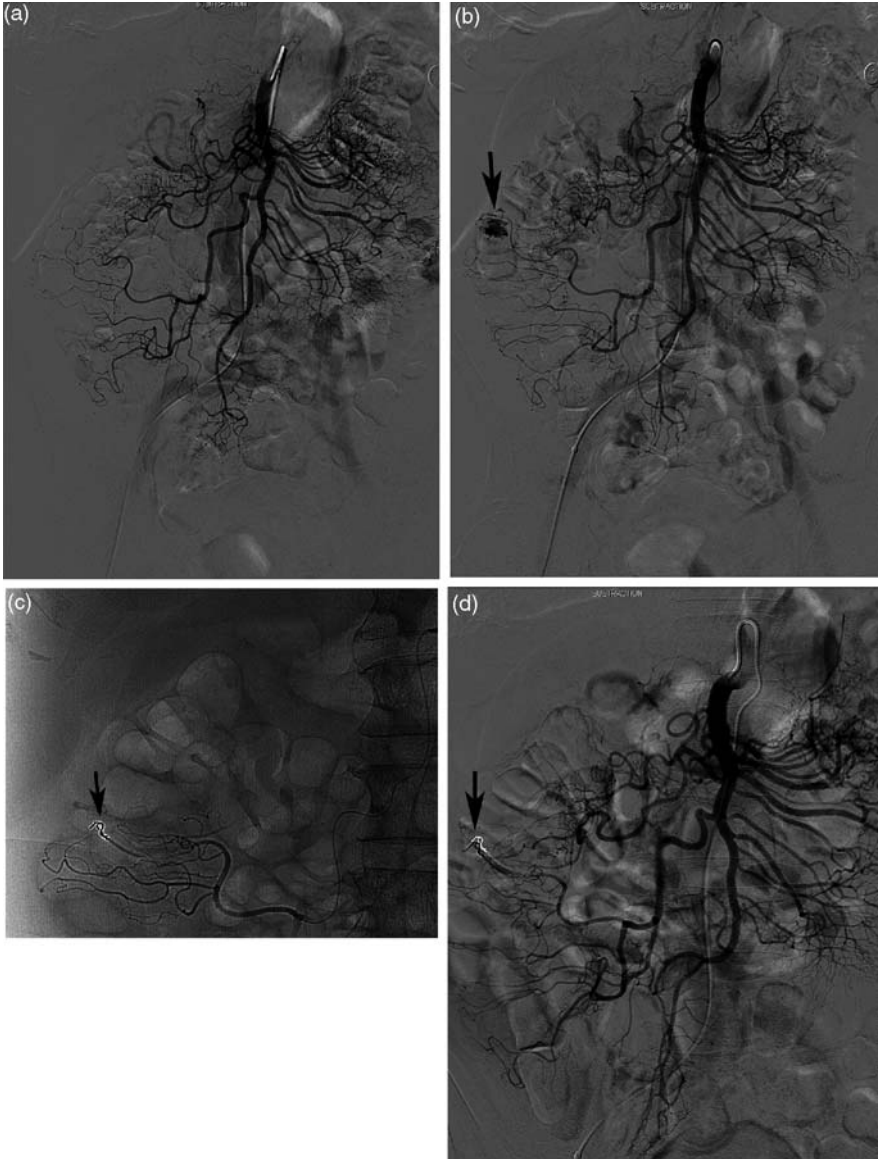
(a) 53-year-old male presents with positive scintigraphy in the hepatic flexure, transient hypotension with prior bleeding episode, and one previous negative arteriogram. Initial injection of the superior mesenteric artery is normal without extravasation. (b) Injection of the superior mesenteric artery following the administration of 5,000 U Heparin, 200 mcg Nitroglycerin, and 4 mg tPA demonstrates active bleeding (*arrow*) from a branch from the right colic which was suspected on scintigraphy. (c) Injection through the microcatheter following placement of coils (*arrow*) within the arcuate branches supplying the area of extravasation. (d) Completion arteriogram demonstrates coils (*arrow*) with no further bleeding and preserved collateral supply to the region of colon
